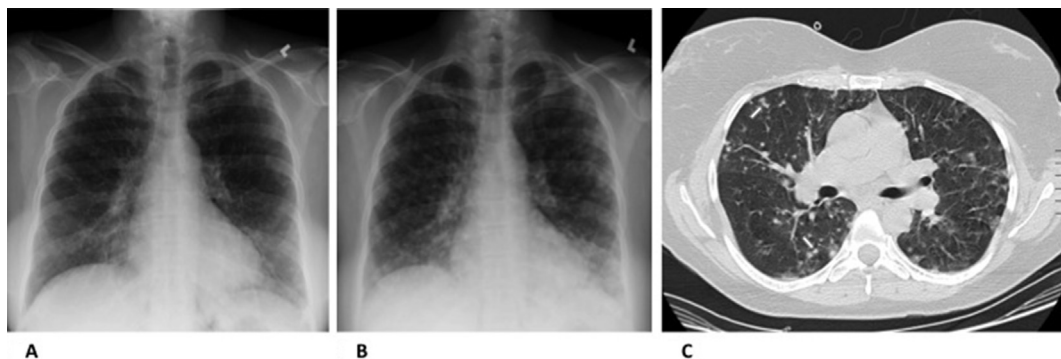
A–B, Successive frontal chest radiographs showing progression of a diffuse nodular infiltrate. C, CT scan of the chest showing numerous ill-defined nodules in a centrilobular distribution (arrows).
